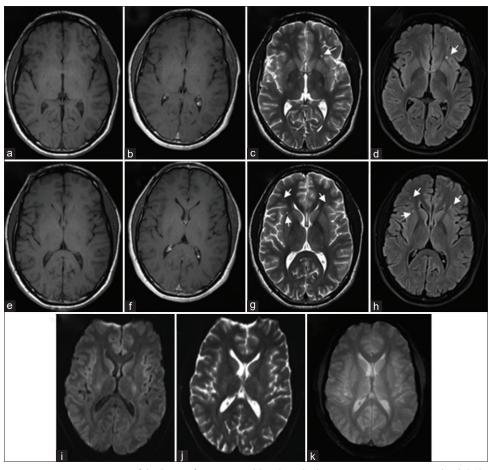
Magnetic resonance imaging images of the brain of a 23-year-old male with chronic progressive external ophthalmoplegia plus. All are axial planes: (a and e) T1WI noncontrasted, (b and f) T1WI postcontrast, (c and g) T2WI, (d and h) Fluid-attenuated inversion recovery (FLAIR), (i) Diffusion-weighted imaging (DWI), (j) Apparent diffusion coefficient (ADC) and (k) Enhanced susceptibility weighted imaging (eSWAN). Findings: Presence of asymmetrical multifocal sub-centimeter lesions of high-signal intensity on the T2W/FLAIR images in subcortical and deep white matter of bilateral frontal lobes and right insula cortex (white arrows). On T1WI lesions are isointense to white matter without enhancement following contrast administration. No abnormal diffusion on DWI/ADC. And no blooming artifacts on eSWAN. Lesions can be described as "unidentified bright objects." No definite lesions are seen in the basal ganglia or thalami. Ventricular system, cisterns, sulci, and other structures were unremarkable
